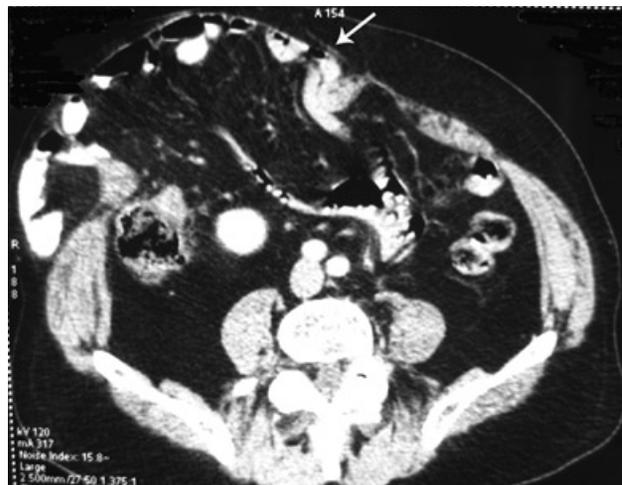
The patient with recurrent subcostal incisional hernia right Computed tomography of the abdominal wall and abdominal cavity showed the recurrent incisional hernia sac containing bowel and residual polypropylene mesh marked by an arrow.
